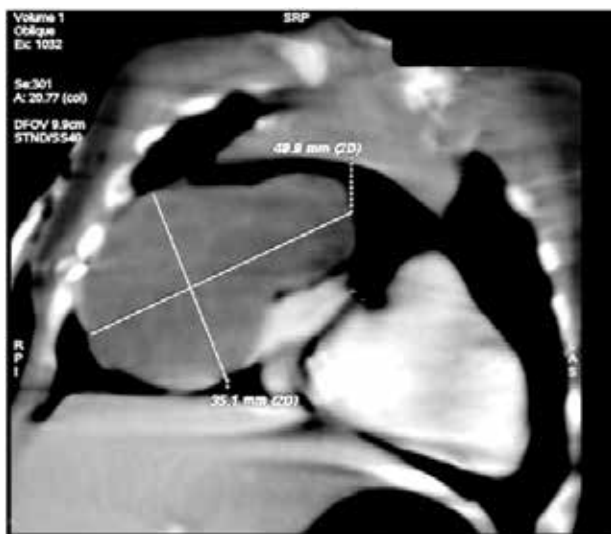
Repeat CT scan showing mass mainly located on the right side of heart.
